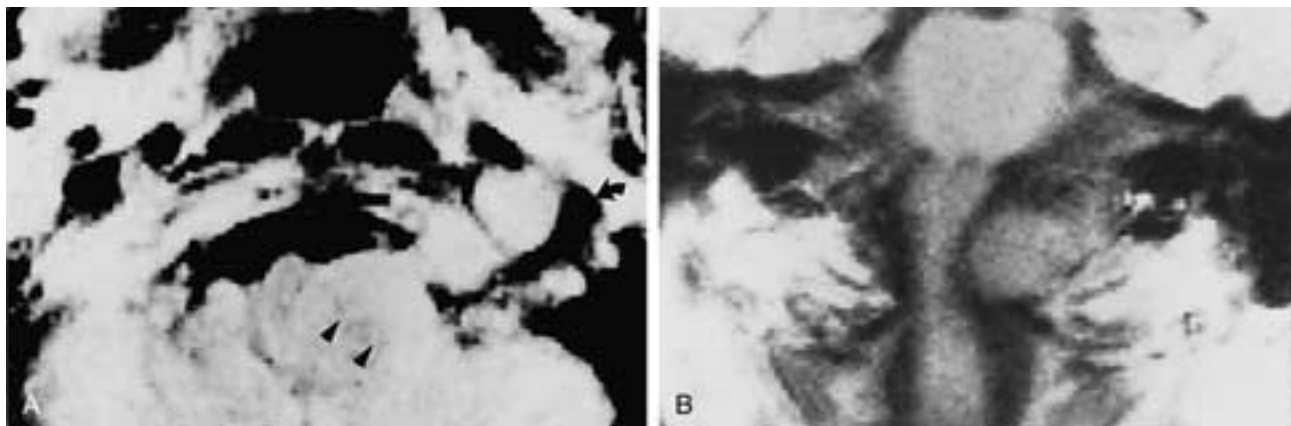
Trilobed hypoglossal schwannoma. A and B, T1-weighted images. The tumor is difficult to distinguish from jugular foramen schwannoma on transverse images, but its more caudal position at the medullocord junction is quite apparent on the coronal image (B). (Compare with Fig. 25-33D). The intracranial component of the tumor deforms the medulla (*arrowheads*), and the parapharyngeal component displaces the jugular vein (*curved arrows*).
